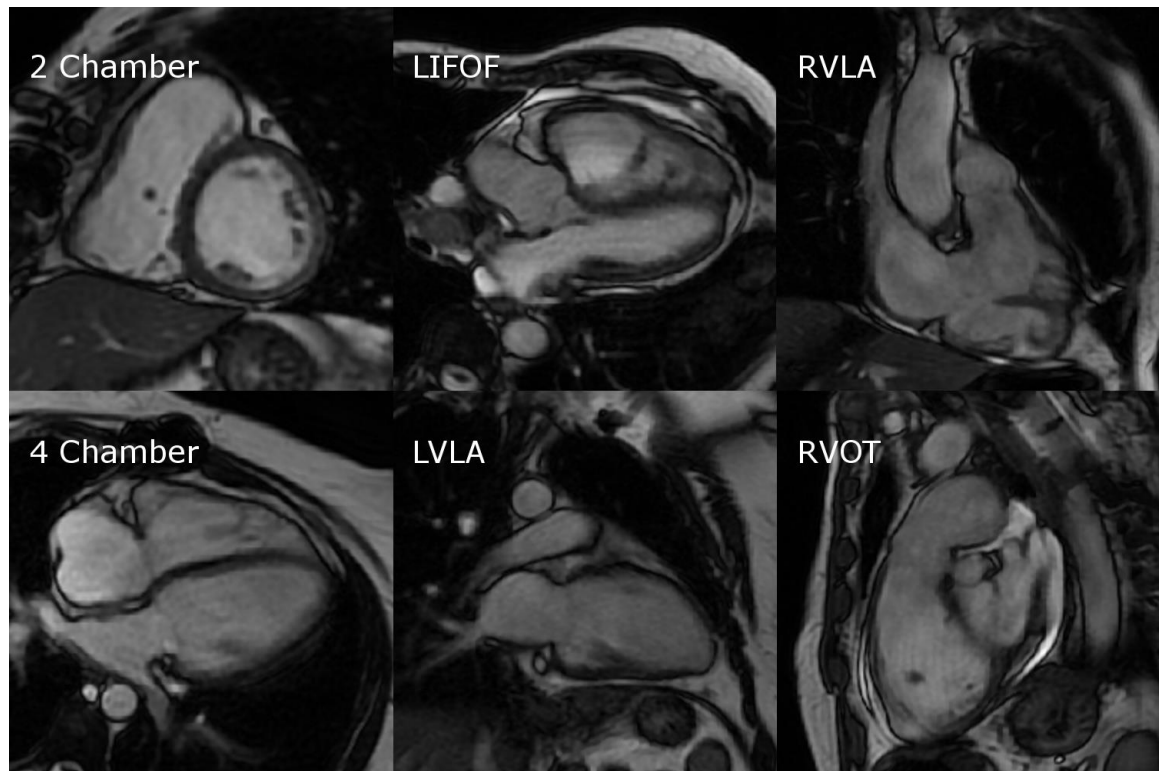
Cardiac MRI SSFP cine views.
